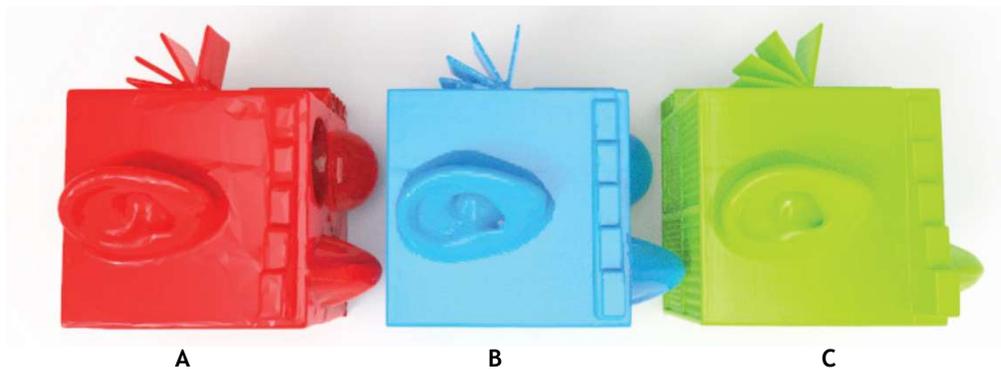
CT Result of Elevation Test Features and Ear for 3D Doctor® (A), Mimics® (B) and Invesalius® (C).
